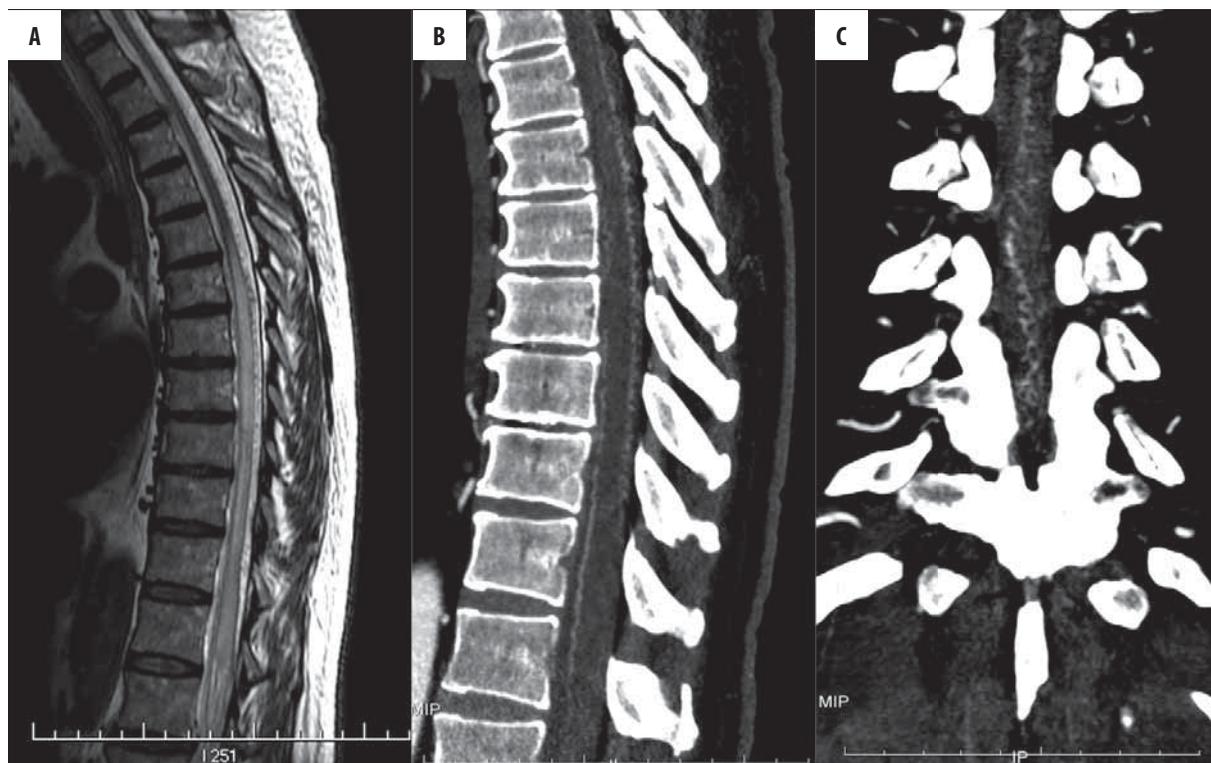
Dural arteriovenous fistula. (A) MRI: T2-weighted sagittal image reveals diffuse spinal cord edema. There are multiple small serpiginous foci of signal void at the surface of the spinal cord which may be compatible with pathological vessels. B, C. CT angiography: sagittal (B) and coronal (C) reconstructions. Pathological vessels of dural arteriovenous fistula are clearly visible.
